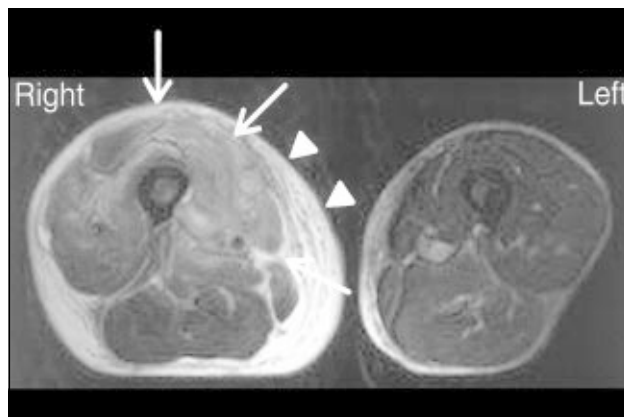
T2-weighted fat suppressed axial image of the mid-thigh showing similar findings to those in Fig 1
